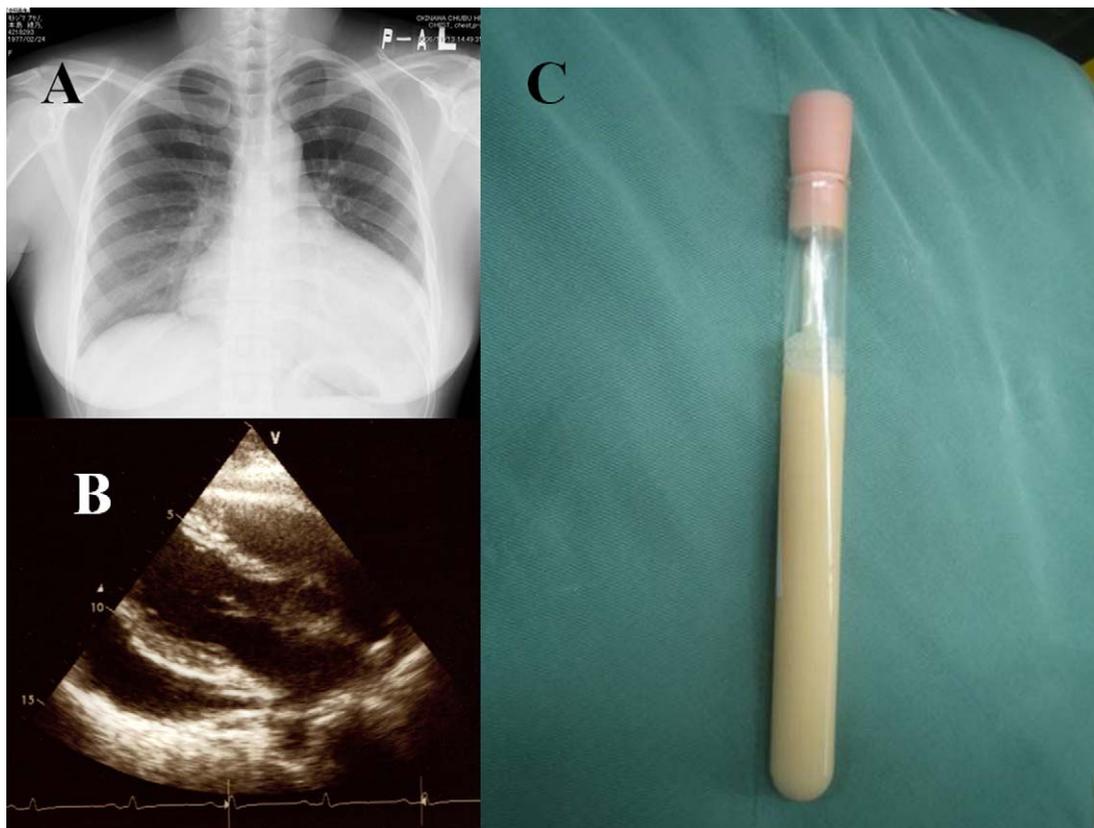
(A) Chest X-ray shows marked cardiac enlargement. (B) An echocardiography demonstrates large amount of pericardial fluid. (C) Chylous fluid obtained by pericardiocentesis.
